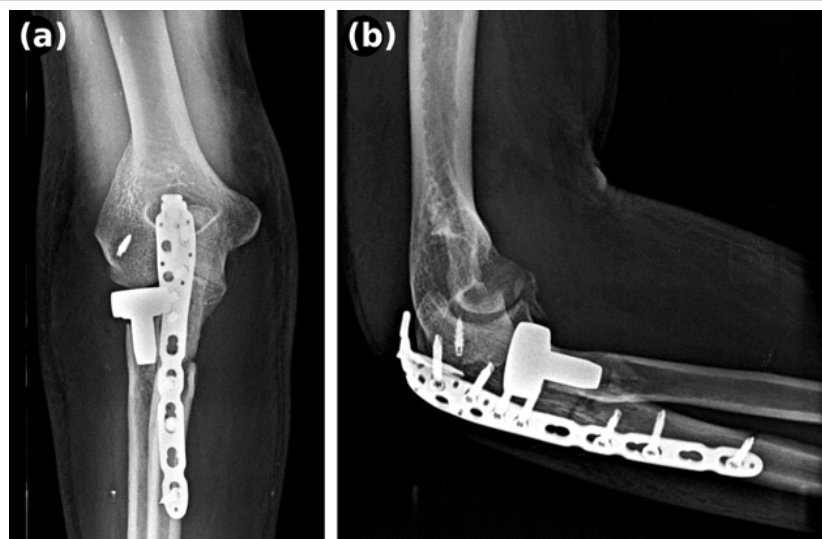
Post-operative plain radiographs. (a) Anteroposterior view showing concentric radial head prosthesis seating and satisfactory ulnar dynamic compression plate alignment. (b) Lateral view confirming appropriate anterior prosthetic positioning and restored ulno-humeral congruence.
